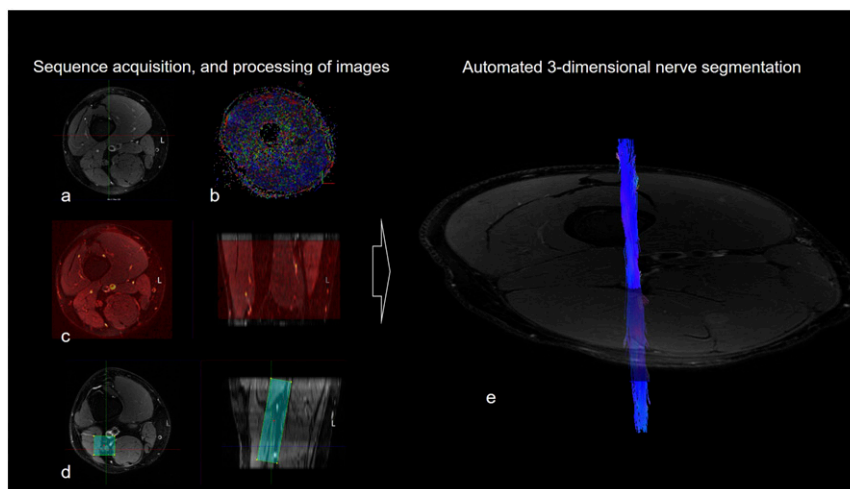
Acquisition and coregistration of MRI sequences with subsequent automated segmentation of the sciatic nerve. *A*: Acquisition of anatomical T2-weighted (T2w), fat-suppressed (FS) sequences of the right thigh. *B*: Automated coregistration of T2wFS and DTI sequences. *C*: Manual selection of nerve region on anatomical T2wFS images. *D* and *E*: Automated three-dimensional segmentation of the sciatic nerve (*D*) and resulting fiber tracts of the sciatic nerve (*E*).
